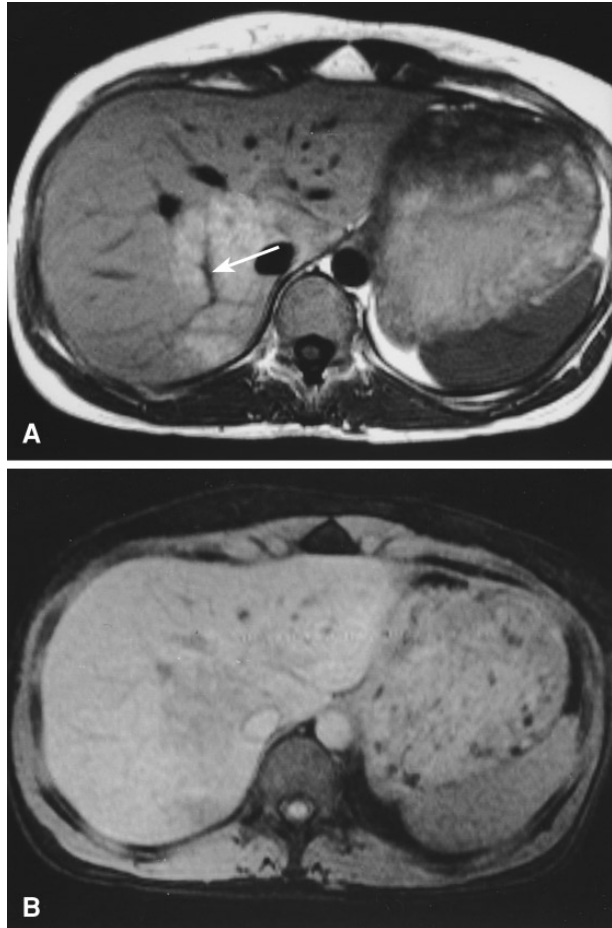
Focal fatty infiltration, multinodular form. A T1-weighted SE image (420/15). Multiple nodules appear hyperintense relative to the liver. Notice the chemical-shift artifact, present close to the fatty areas, in the frequency-encoding direction (arrows). B Fat-suppressed T1-weighted images (420/15). The nodules are hypointense relative to liver.
